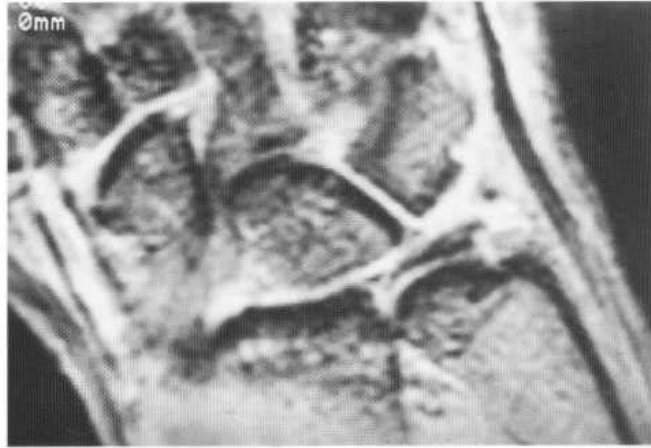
MRI of the triangular cartilage. There is bright signal within the bulk of the triangular cartilage extending to its distal surface.
